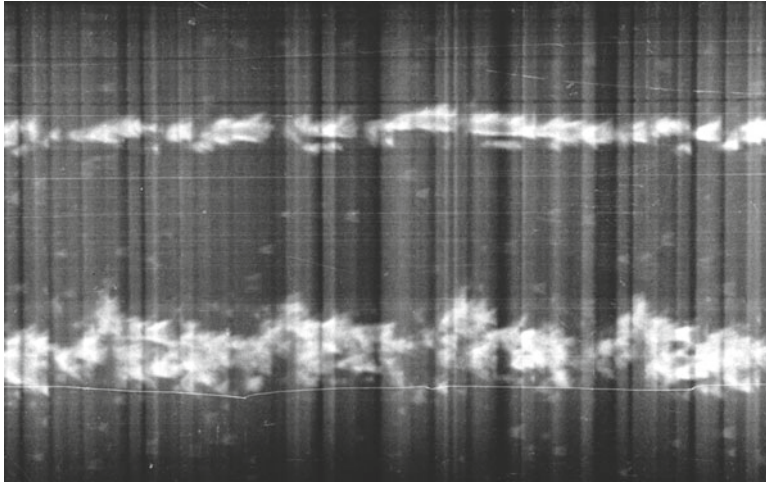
First “motion-mode,” or M-mode, tracing displaying ultrasonic tracings of moving cardiac structures. From [23]
